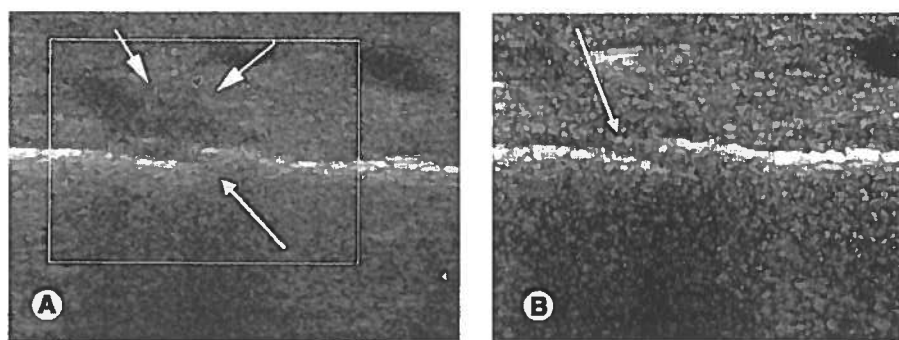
(A) Transplant patient, radius. Color Doppler ultrasound performed at week 3 shows vessels near the osteotomy site. Arrows: vessels, diameter approximately 1 mm. (B) Ultrasound B mode performed at week 3: longitudinal scan of the radius shows the osteotomy site (arrow).
